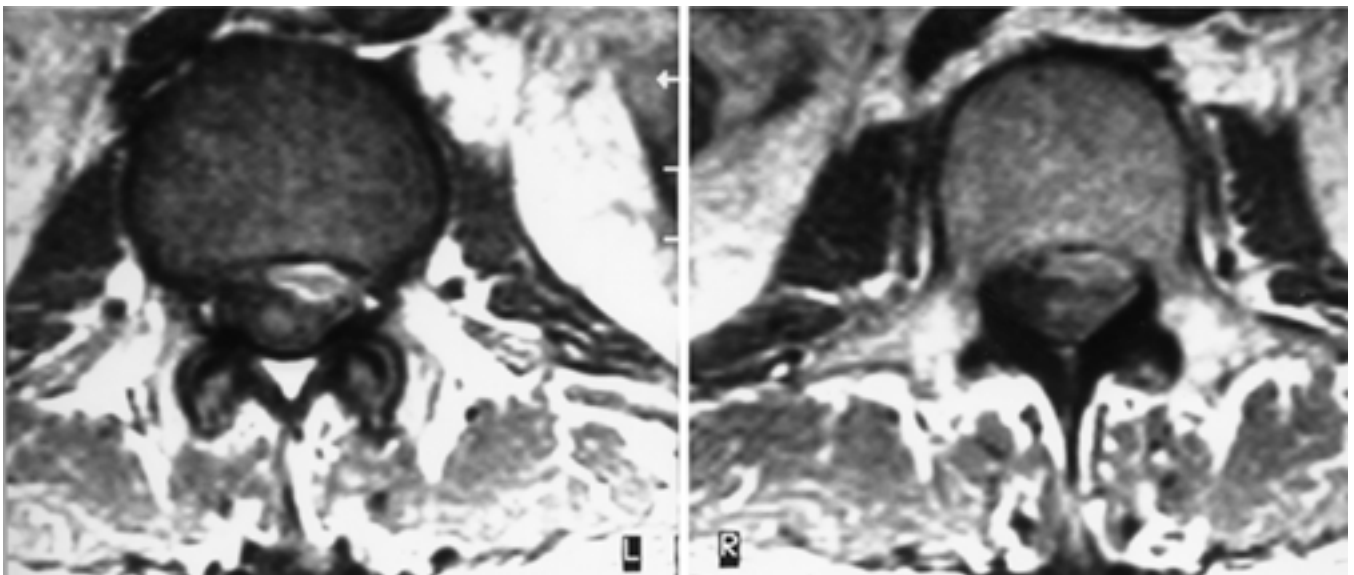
Axial T₁-weighted MR images demonstrating a hyperintense mass at L-1.
